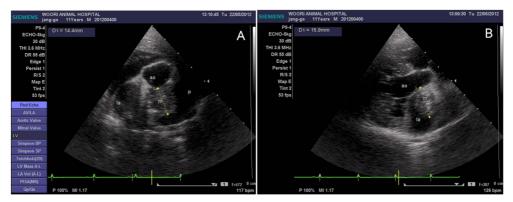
Echocardiogram images obtained from the case 1. The right parasternal short axis (aortic level; A) and long axis (5 chamber view; B) of 2 D echocardiography showed 14-16 mm mass grown among ascending aorta, pulmonary artery and left atrium.
